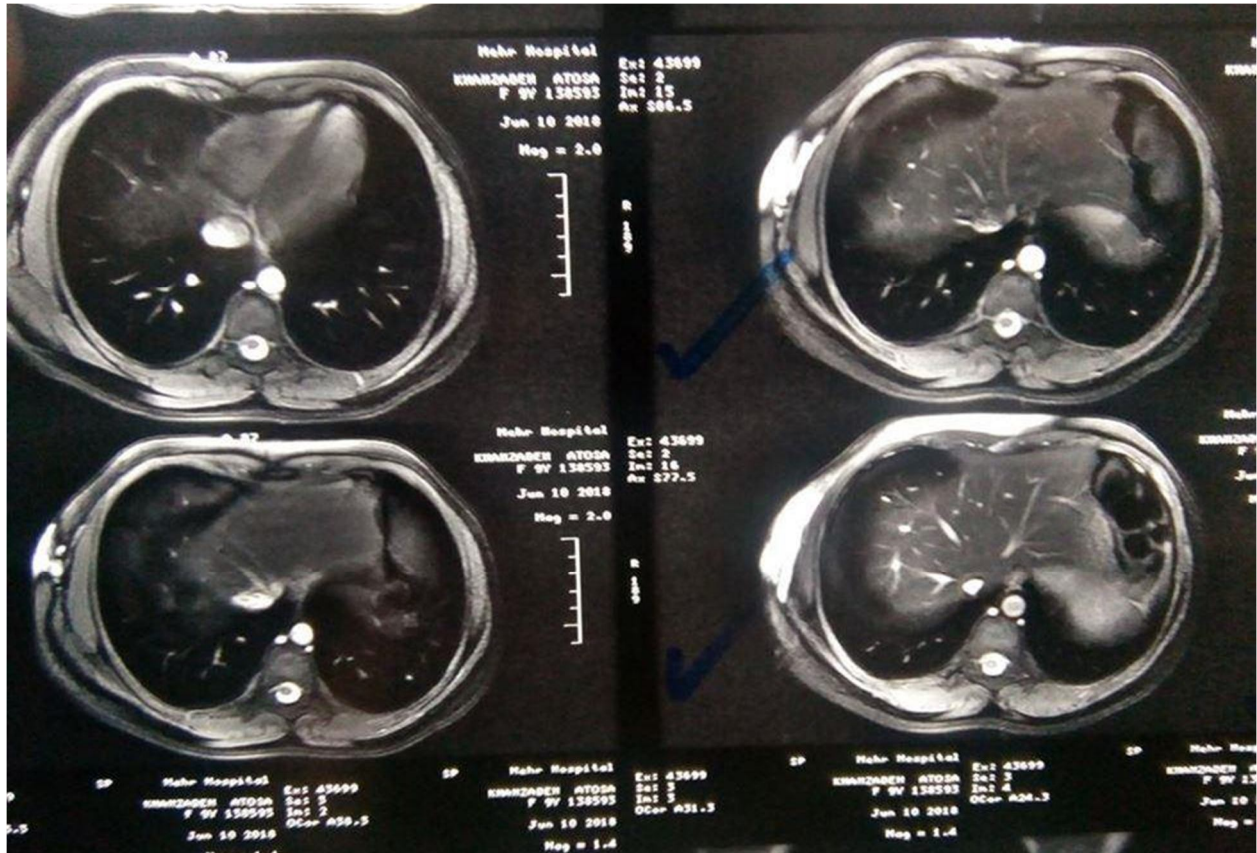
MRI of the chest.T2-weighted, with contrast and with fat suppression.
